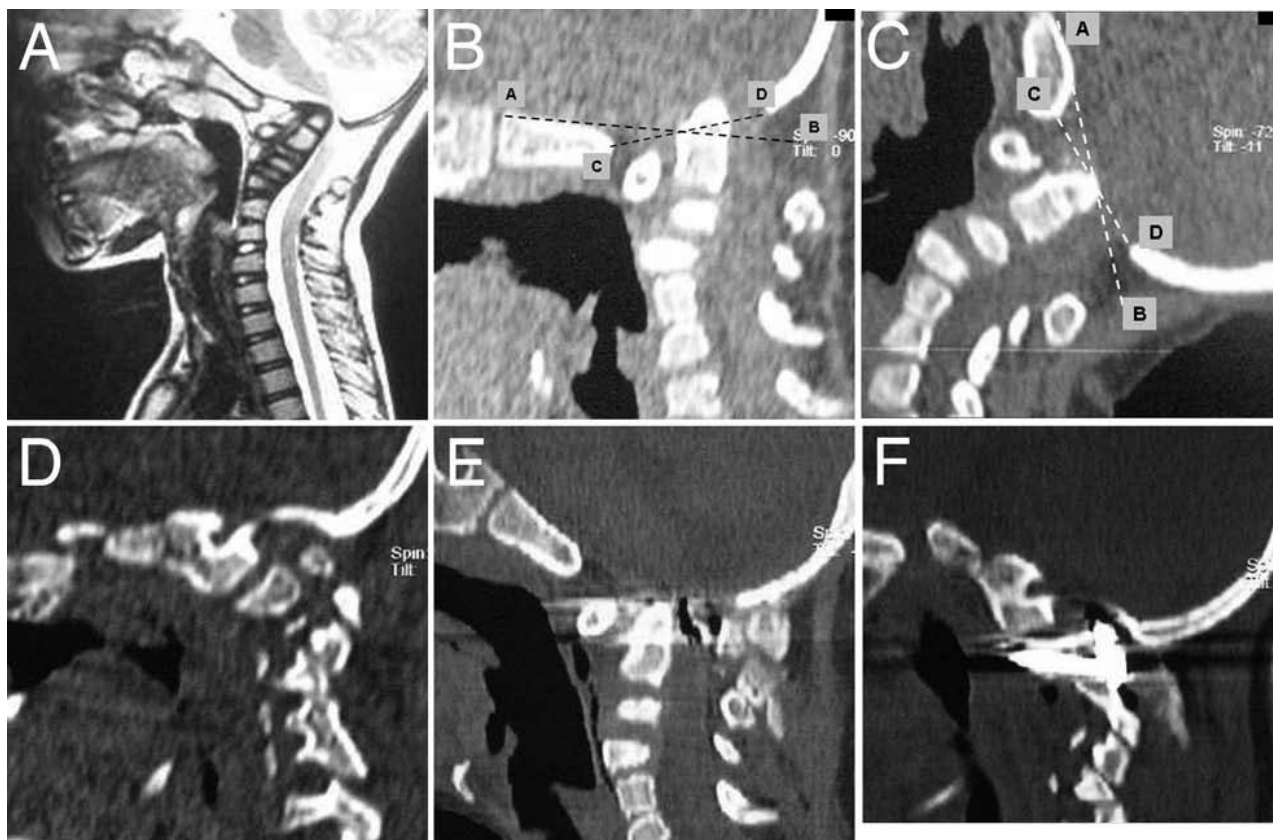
Neuroimages obtained in an 8-year-old girl with unstable basilar invagination. A: Sagittal T2-weighted MR image showing extensive basilar invagination and cervicomedullary spinal cord compression. B: A CT scan reconstruction with the head in flexed position showing severe basilar invagination and vertical atlantoaxial dislocation. The Wackenheim clival line (A---B) and the McRae foramen magnum line (C---D) show the relationship with the odontoid process. C: A CT scan with head in extension showing reduction of dislocation. Note the altered relationship of the odontoid process with the McRae line and the Wackenheim line. D: A CT scan with the sagittal cut passing through the atlantoaxial joint. An abnormal oblique orientation of the joint can be appreciated. E: Postoperative CT scan showing fixation of the dislocation by using the lateral mass plate and screw fixation method. Reduction of the vertical dislocation can be appreciated. F: Postoperative sagittal CT scan showing plate and screw fixation and realignment of the joint.
